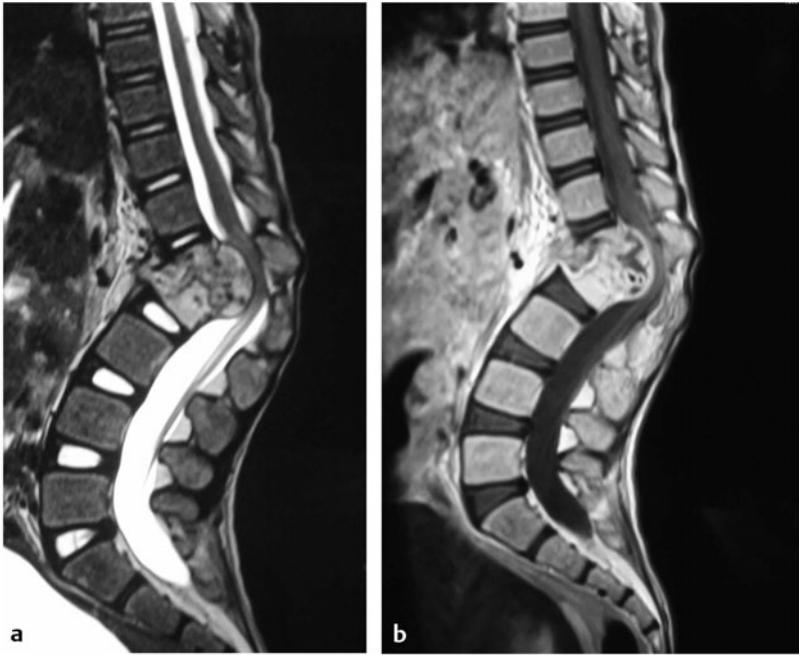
(a,b) Lumbar spine tuberculosis. Eight-year-old, girl with chronic backache for last year. Physical examination: back deformity (low lumbar-dorsal kyphosis), painful on palpation, mild paraparesis 4-/5, sphincter dysfunction, hypotrophic lower limbs, hyperreflexia, and moderate spasticity. T1 and T2 MRI sequences reveal destruction of the vertebral body T12,L1,L2, respecting disk of T11 and L2, severe kyphoscoliosis with compression of the conus medullaris. There is a paravertebral abscess over both psoas. She went to surgery: laminectomy from T12, L1,L2, corpectomy of L1,L2 utilizing fibula as bone graft plus transpedicular screw placement in T11,T10 – L3,L4 plus rods and cross link. Previously, both paravertebral collections were evacuated to reveal caseum. Laboratory confirmed Koch bacille: Pott disease. (Case kindly provided by Dr. José Efraín García Reyes, Hospital Nacional Guillermo Almenara Irigoyen-Lima, Peru.)
